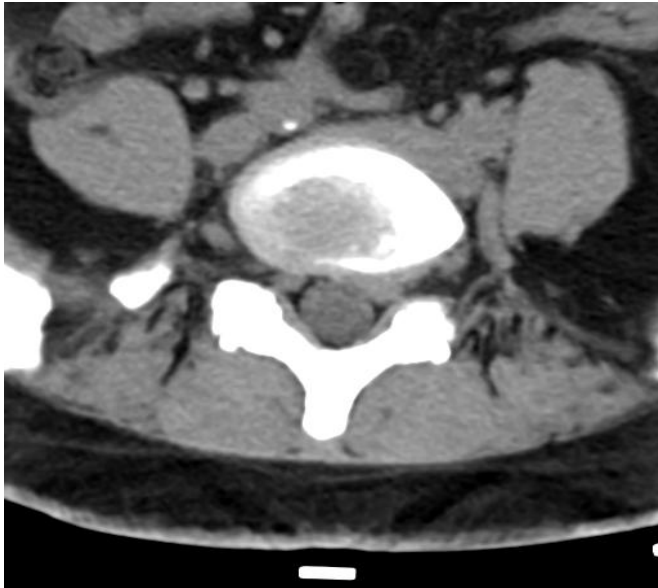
Axial CT image of L5-S1 disc exhibits a large intraforaminal disc protrusion traversing the left S1 nerve root (reading right) as well as posterior joint arthropathy and thickening of the ligamentum flavum. Of coincidental note is a small calcific lesion anterior to the spine indicative of mild atherosclerotic plaquing in the descending right common iliac artery. Arterial plaquing was also visualized on several other images in this series.
